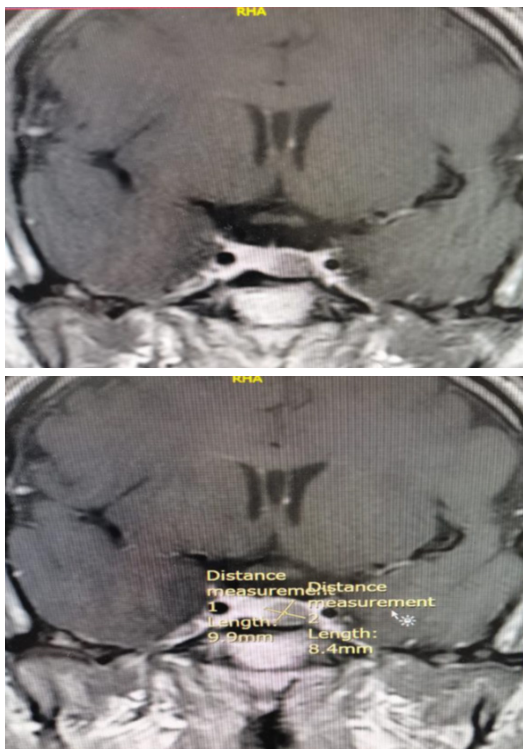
Sagittal pituitary MRI.
